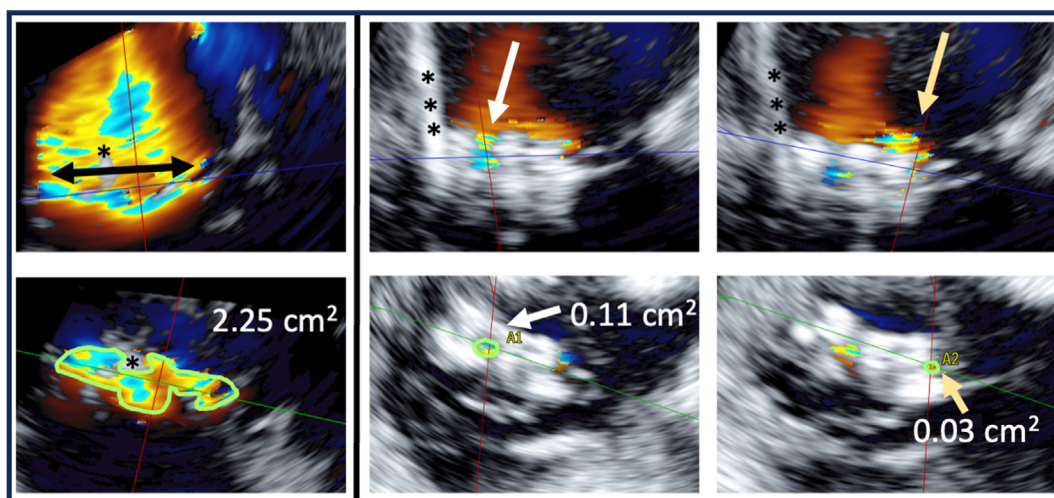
Three-dimensional echocardiography for TR quantification after T-TEER. Torrential (with also incidental presence of a pacer-maker lead, asterisks) TR with a VCA of 2.25 cm² before the procedure (left). After the implantation of three T-TEER devices, two mild residual jets were detected between the devices. The posterior jet had a VCA of 0.11 cm² (middle), and the anterior jet had a VCA of 0.03 cm² (right).
